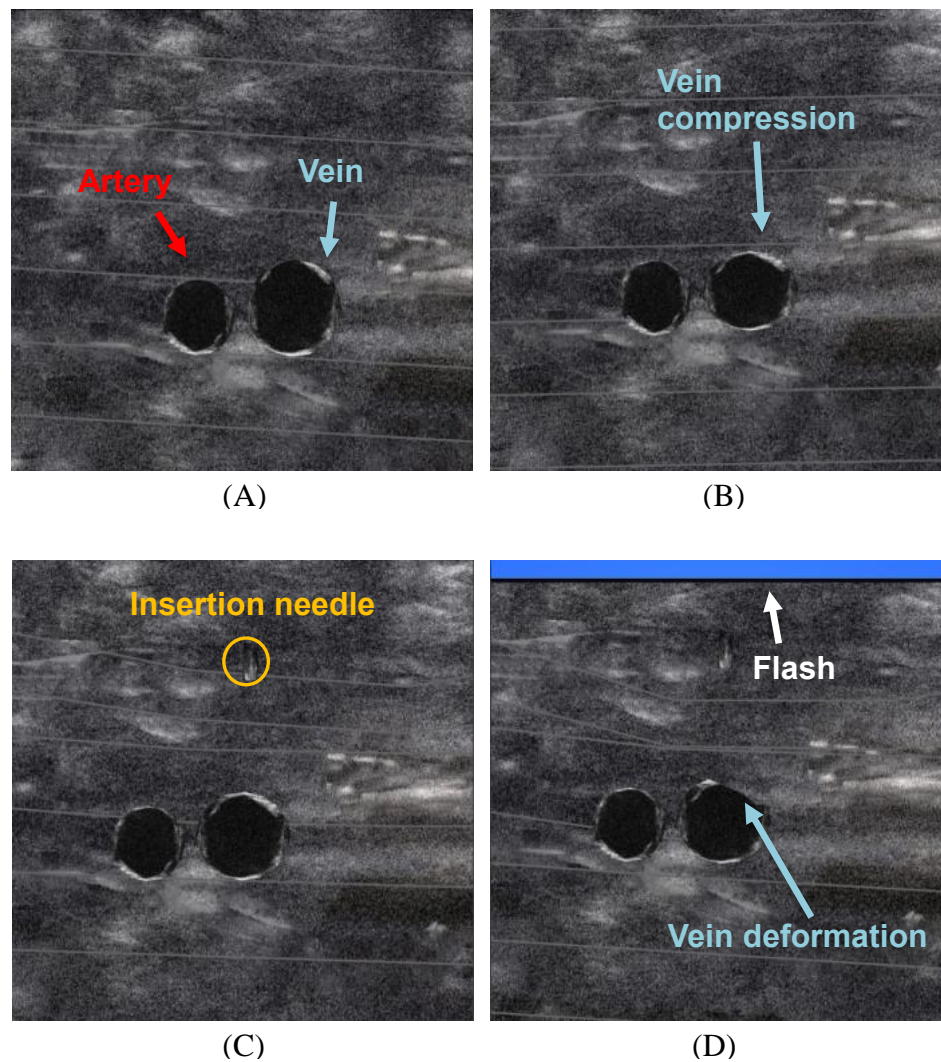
Virtual ultrasound during different stages of needle insertion: (A) finding vessels, (B) determine vein by checking for compressibility, (C) identify where needle crosses the ultrasound plane, (D) vein deformation and needle flash appears during successful insertion.
